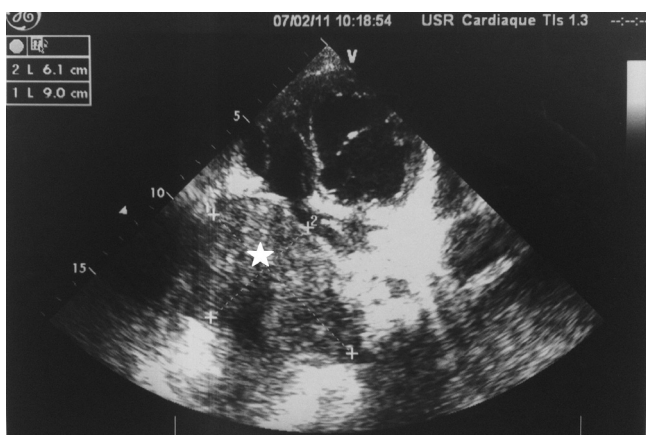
Echocardiography showing a right lateral atrial intra-pericardial mass (white star).
